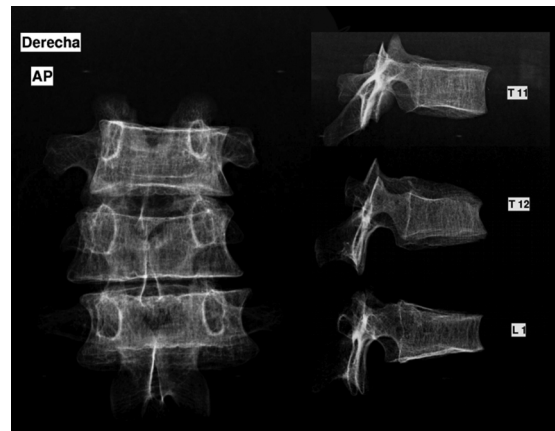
X-ray images of T11, T12 and L1 of Myren 1. No lytic lesions were observed in the images. These vertebrae were apparently affected by osteopenia and anterior compression of L1 is clearly visible (below right).
